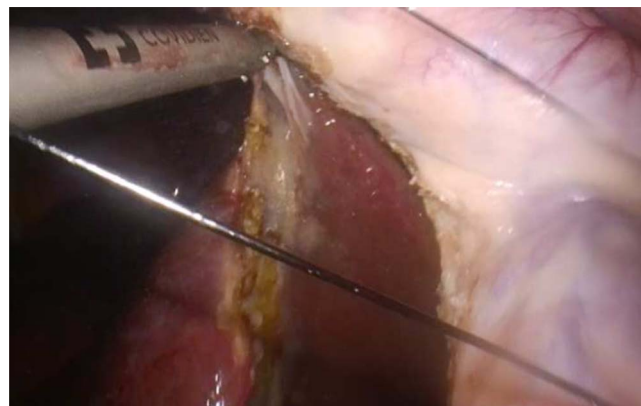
Dissection of the gallbladder off the cystic plate with an ultrasonic scalpel. Tension is maintained on the sutures through the fundus and body to facilitate dissection.
